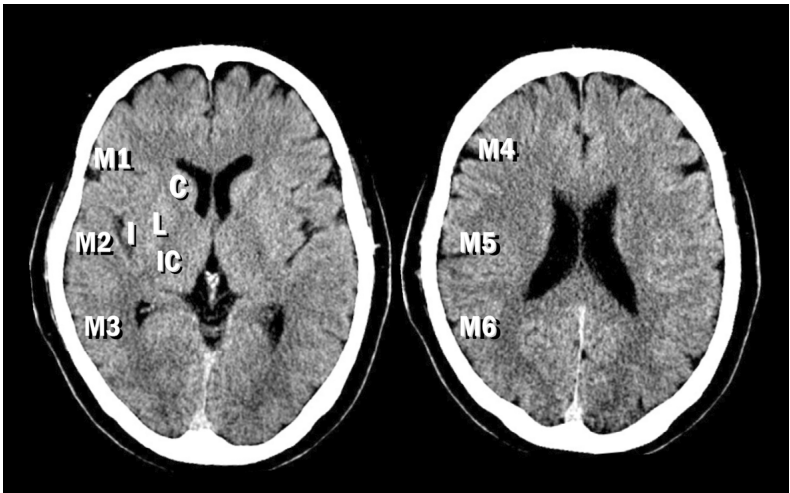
Ten Alberta Stroke Programme Early CT Score (ASPECTS)-defined regions in the MCA territory for the performance evaluation on unenhanced CT images. These regions include lentiform nucleus (L), insula (I), caudate nucleus (C), internal capsule (IC), anterior inferior frontal lobe (M1), temporal lobe (M2), inferior parietal and posterior temporal lobe (M3), anterior superior frontal lobe (M4), precentral and superior frontal lobe (M5), and superior parietal lobe (M6).
